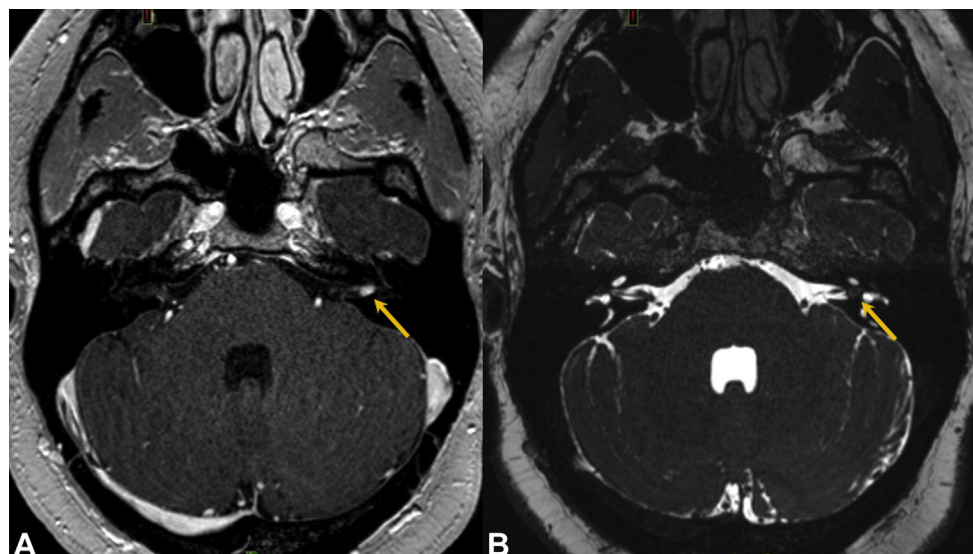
Preoperative magnetic resonance imaging showing an intracanalicular contrast-enhancing lesion (yellow arrows) in the left internal auditory canal
